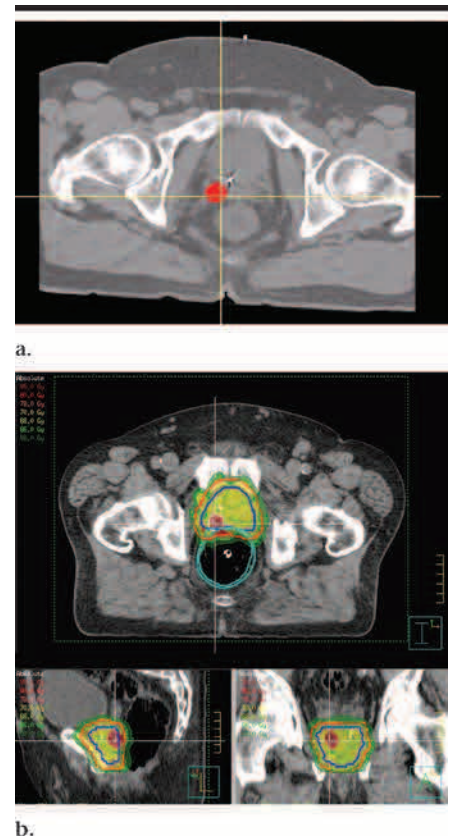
Images show (a) registered tumor map overlaid in red on top of transverse treatment-planning CT image and (b) radiation therapy treatment plan. Notice how boost dose area conforms to DIL area demonstrated at MR imaging.
